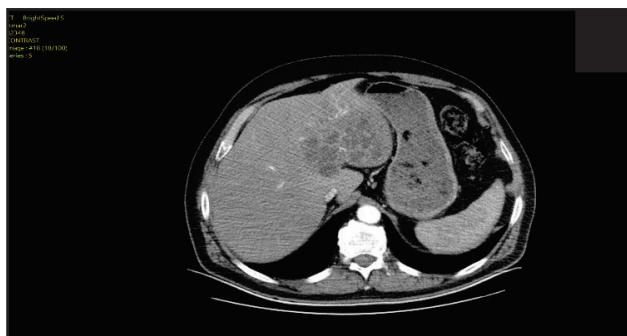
CT-scan of the liver abscess
